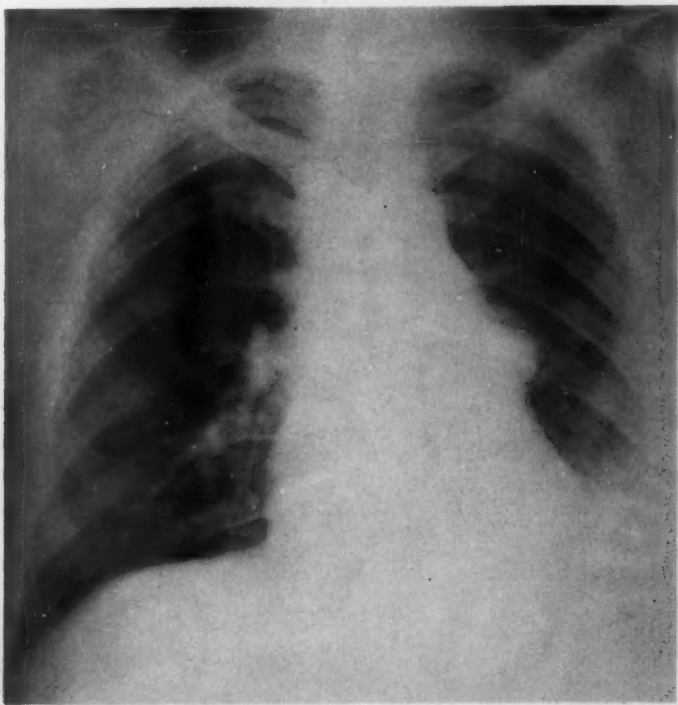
The posterior-anterior x-ray examination of a 32 year old barber who, because of slight fever and cough, was admitted to the hospital. The roentgenographic study shows a rounded prominence of the left cardiac border and a left-sided pleural effusion.
